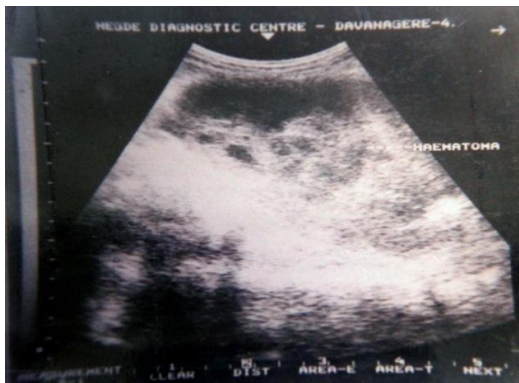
Retroperitoneal Hematoma-ultrasound
